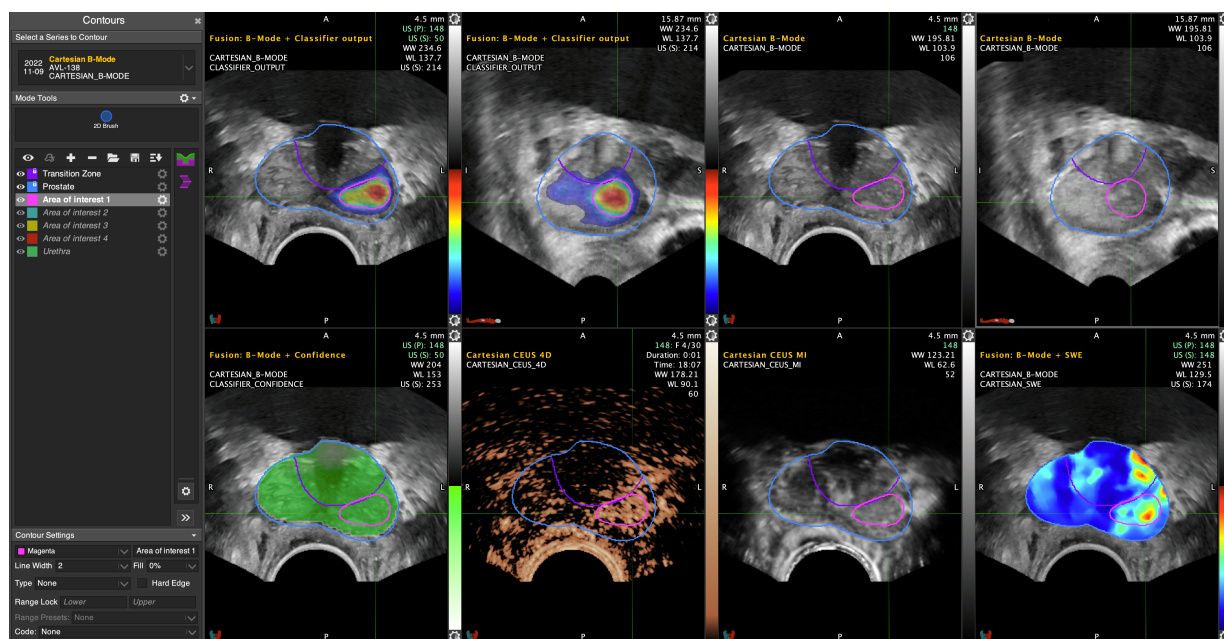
PCaVision GUI. HP1: axial B-mode overlaid with classifier output. HP2: sagittal B-mode overlaid with classifier output. HP3: axial B-mode. HP4: transversal B-mode. HP5: axial B-mode overlaid with confidence map. HP6: axial 4D CEUS movie. HP7: axial CEUS MI. HP8: axial B-mode overlaid with SWE. The prostate and PZ/TZ zone contour are visible in all series. In the left tab, the contours can be seen. Delineation of the AOI in one series will automatically be projected in the other series. GUI = graphical user interface; HP = hanging position; B-mode = brightness-mode; SWE = shear wave elastography; 4D = 4-dimensional; CEUS = contrast-enhanced ultrasound; MI = mean intensity; PZ = peripheral zone; TZ = transition zone; AOI = area of interest.
